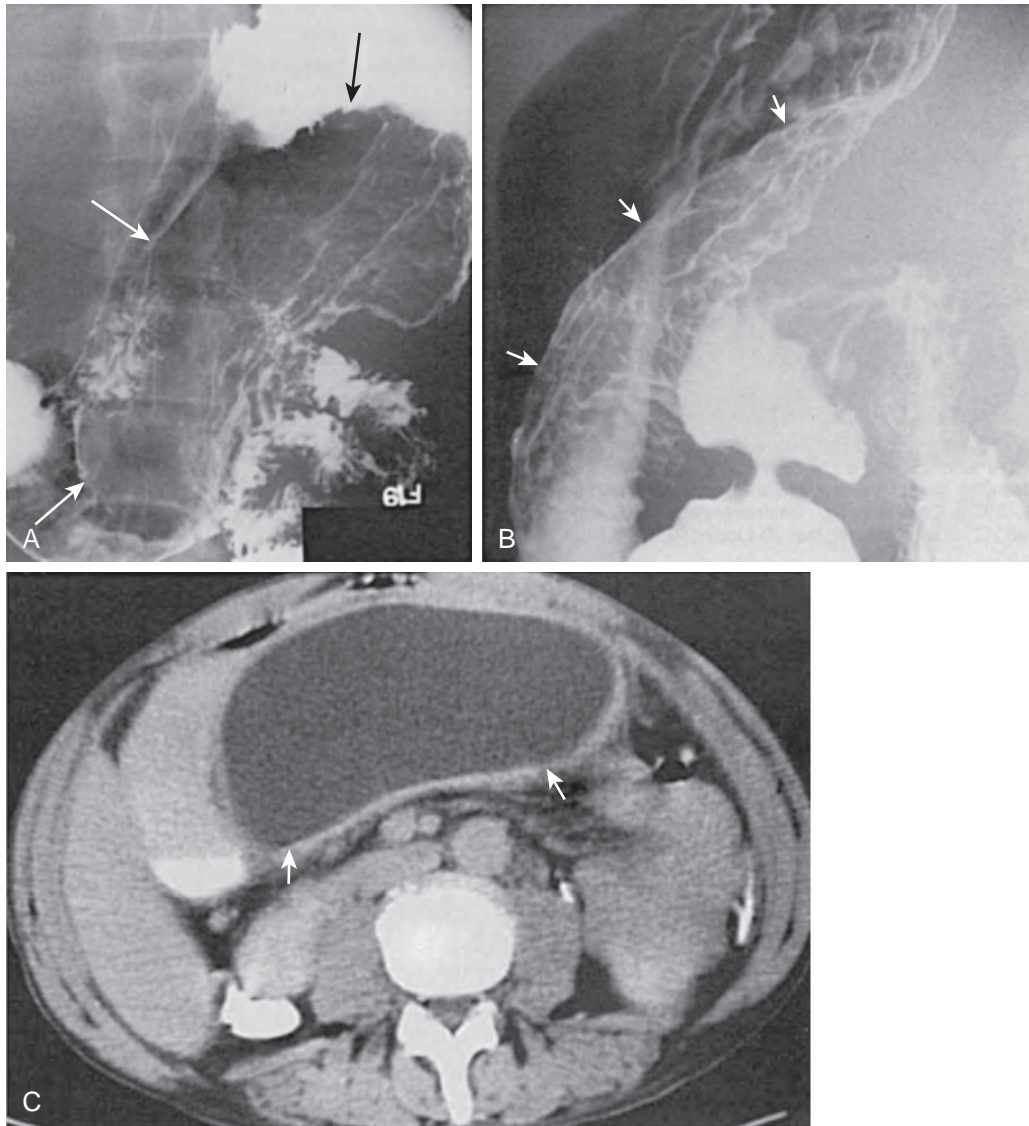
Gastric involvement by a pancreatic pseudocyst. A. Supine view of the stomach shows a large area of extrinsic mass effect (arrows) on the upper gastric body. B. Lateral view shows the retrogastric mass (arrows) in profile. C. CT scan reveals a large pancreatic pseudocyst (arrows) compressing and displacing the stomach. (From Laufer I, Levine MS [eds]: *Double Contrast Gastrointestinal Radiology*, 2nd ed. Philadelphia, WB Saunders, 1992.)
